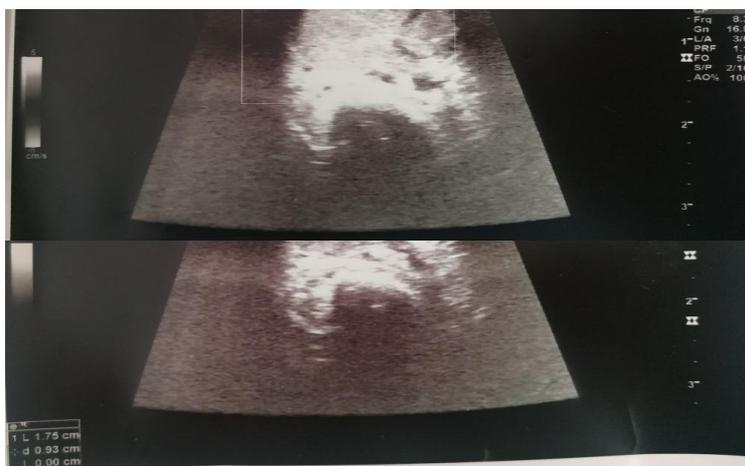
Ultrasonographic appearance of the tumor.
